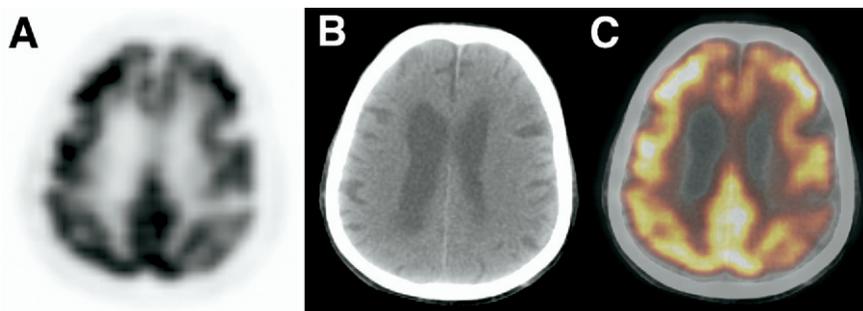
Axial PET (A), CT (B), and fused PET/CT (C) images through frontal lobe of elderly adult brain. Both brain volume and metabolic activity are decreased compared with younger adult brain.
